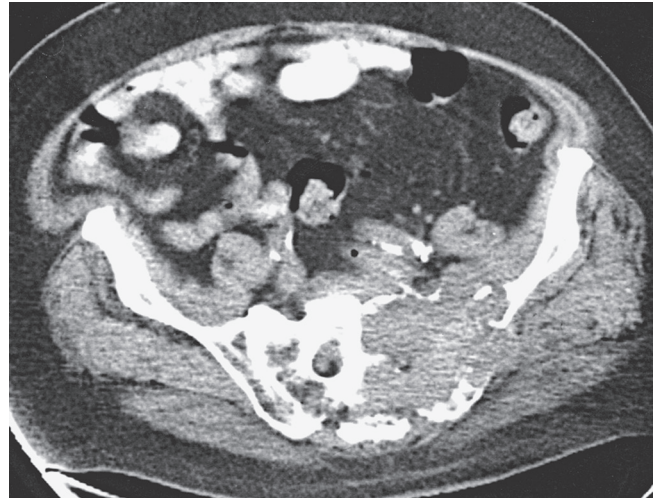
Diagnostic computed tomographic scan of pelvic plasmacytoma. Plain radiographs revealed only rarefaction and were not diagnostic.
